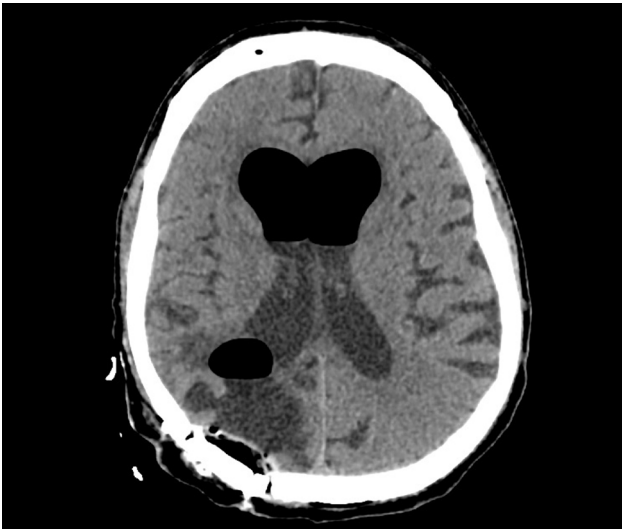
Axial CT scan of a patient who underwent CLD for post-traumatic CSF fistula and pneumocephalus in the lateral ventricles and post-traumatic encephalomalacia in the right occipital region are apparent.
